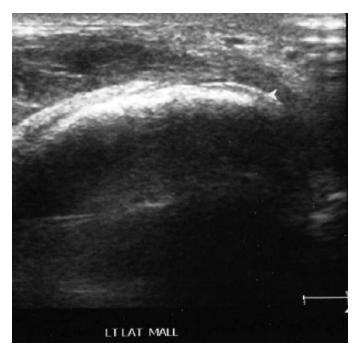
Diagnostic ultrasound of lateral aspect of left ankle. The arrowhead shows fragmentation of the left lateral malleollus.
